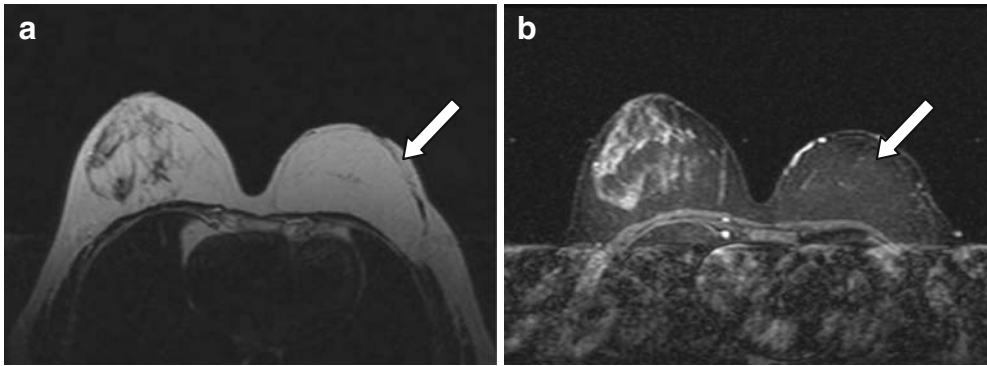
Case number 2818 of October 25th, 2004; 53 year-old patient, right skin sparing mastectomy and reconstruction with TRAM flap in 2002; T2-weighted sequences with (A) and without (B) fat suppression in the axial plan showing the skin and the subcutaneous fat tissue of the left breast (white arrows).
